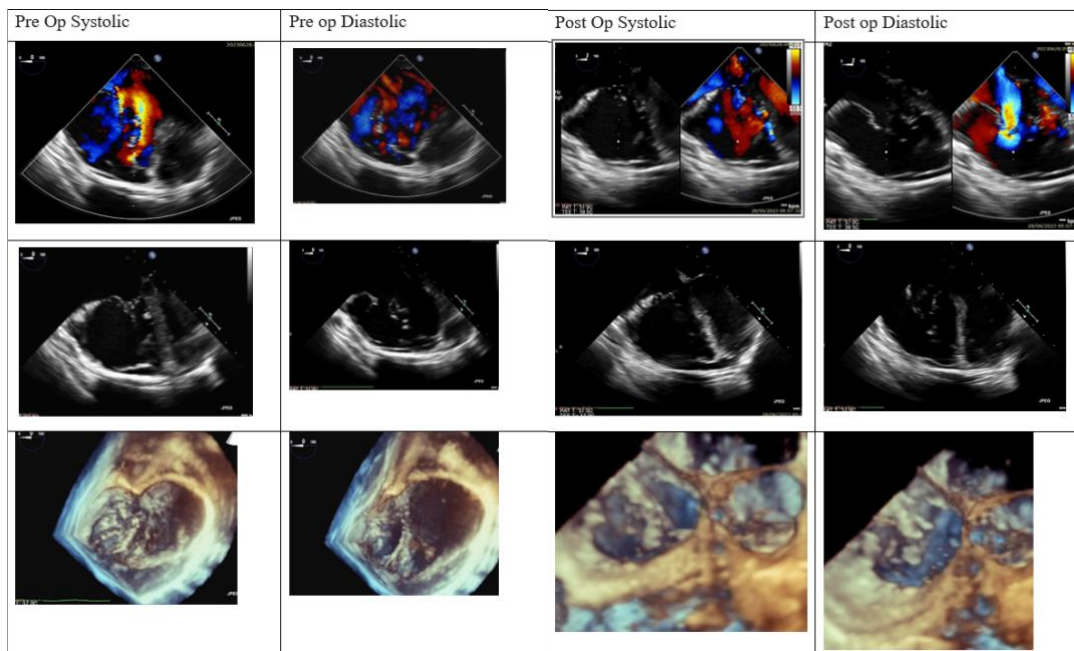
Transesophageal echocardiography before and after procedure
